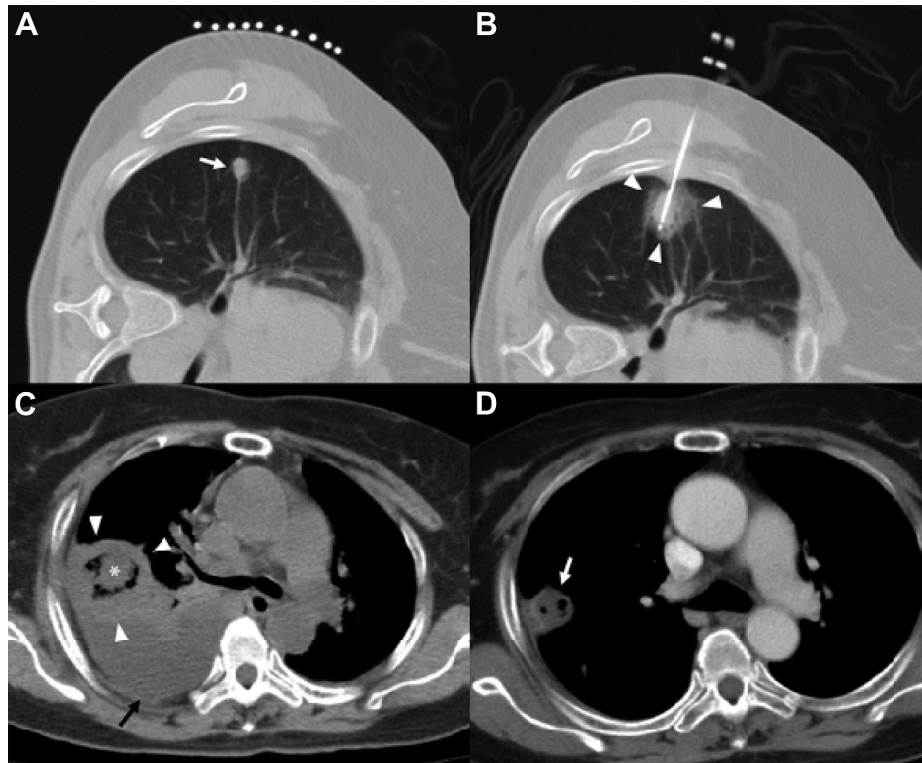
Serial images of the radiofrequency ablation for a 76-year-old female who had colorectal cancer with lung metastasis. (A) A preprocedural image showing the lesion (arrow). (B) An electrode in the lesion with perilesional ground glass opacity (arrowheads), which provides an estimate of the ablation zone. (C) A computed tomography (CT) image 1 week after ablation showed cavitation of ablation zone (arrowheads) covering the original tumor (asterisk). Pleural effusion is noted (arrow). (D) A CT image 1 month after the procedure showed that the ablation zone is of low density, lacks nodular enhancement, and contains small gas bubbles (arrow).
